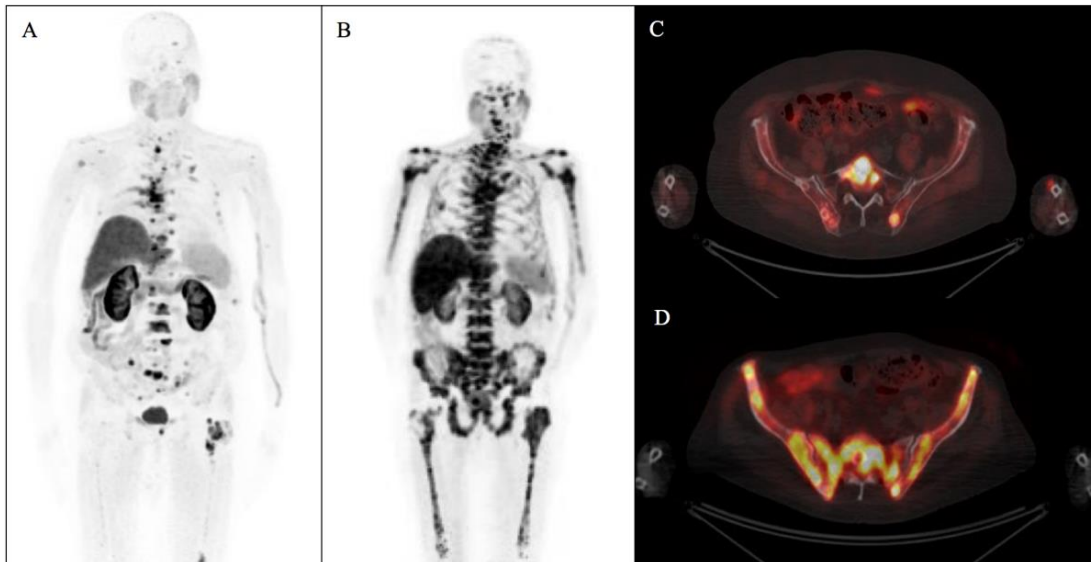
^{18}F -FCH PET/CT (A) MIP and (C) axial fused pre-treatment images and (B) MIP and (D) axial fused post-IV dose images performed in an 85 years old patient affected by CRPC, GS 8. Ra223-therapy has been preceded by chemotherapy and abiraterone therapy. (A, C) Pre-treatment ^{18}F -FCH PET/CT showed high tumor burden (≥ 20 bone lesions). He started Ra223 therapy, but after the IV dose (B, D) ^{18}F -FCH PET/CT showed disease progression, leading to stop radiometabolic therapy.
